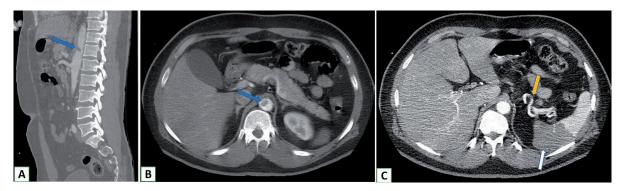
Contrast-enhanced computed tomography (CECT) of the abdomen; sagittal (A) and axial (B and C) images show a small non-enhancing filling defect in the abdominal aorta (blue arrows) and splenic artery (yellow arrow) significant of thrombus. Associated partial splenic infarction is presented in picture C (white arrow)
